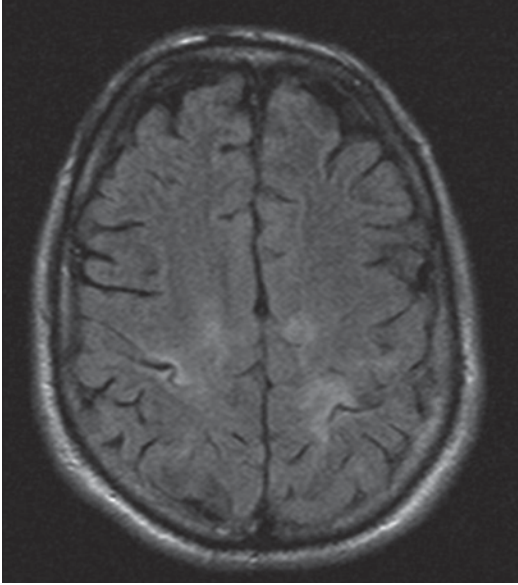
Axial, T2-weighted MRI showing bilateral multifocal cortical areas of increased signal in a 49-year-old male with a 1-week history of headache, fever, stiff neck, and delirium. CSF studies revealed a mild lymphocytic pleocytosis and serum IgM for West Nile virus was present. (Courtesy of Dr. Blaine Hart)
